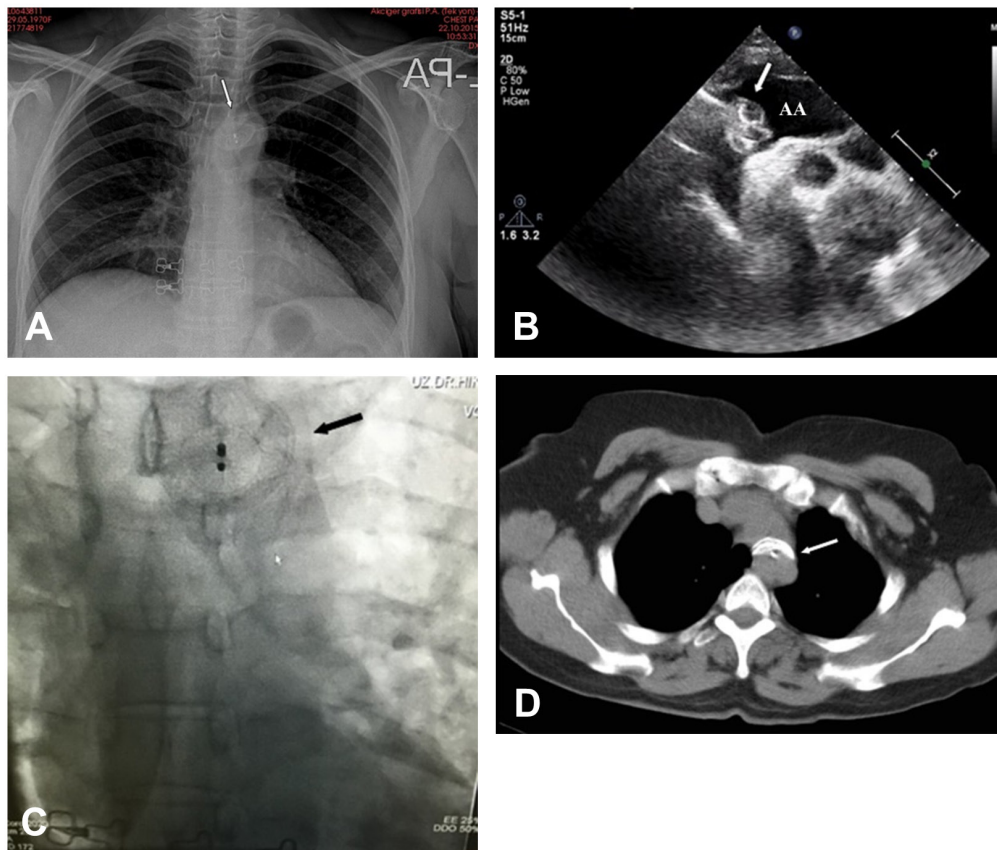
The images on admission. (A), Chest x-ray showing the device migration into the aortic arch. (B), Transthoracic echocardiography showing atrial septal defect occluder device embolized into aortic arch. (C), Fluoroscopy showing atrial septal defect occluder device embolized into aortic arch. (D), Thorax computed tomography showing atrial septal defect occluder device embolized into aortic arch.
